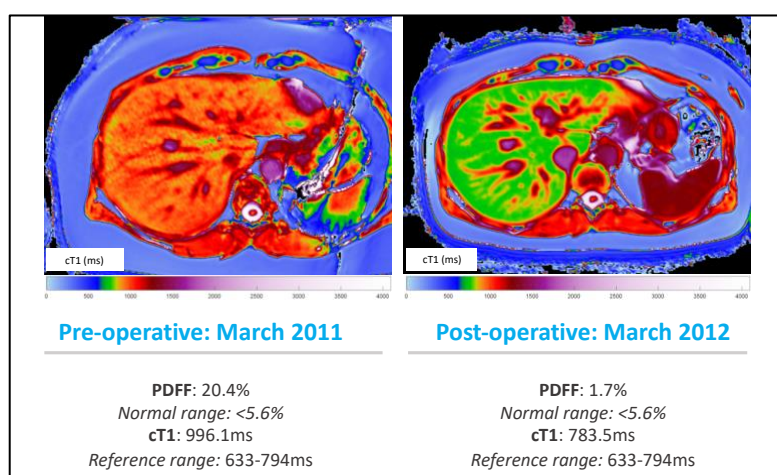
Example of MRI metrics and images from LiverMultiScan™ before and after bariatric surgery
